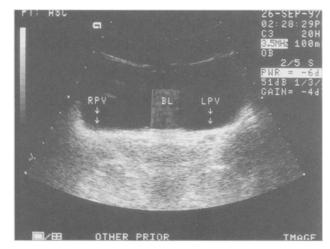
Transverse suprapubic view of patient with full bladder and without ultrasound evidence of paravaginal defects.
